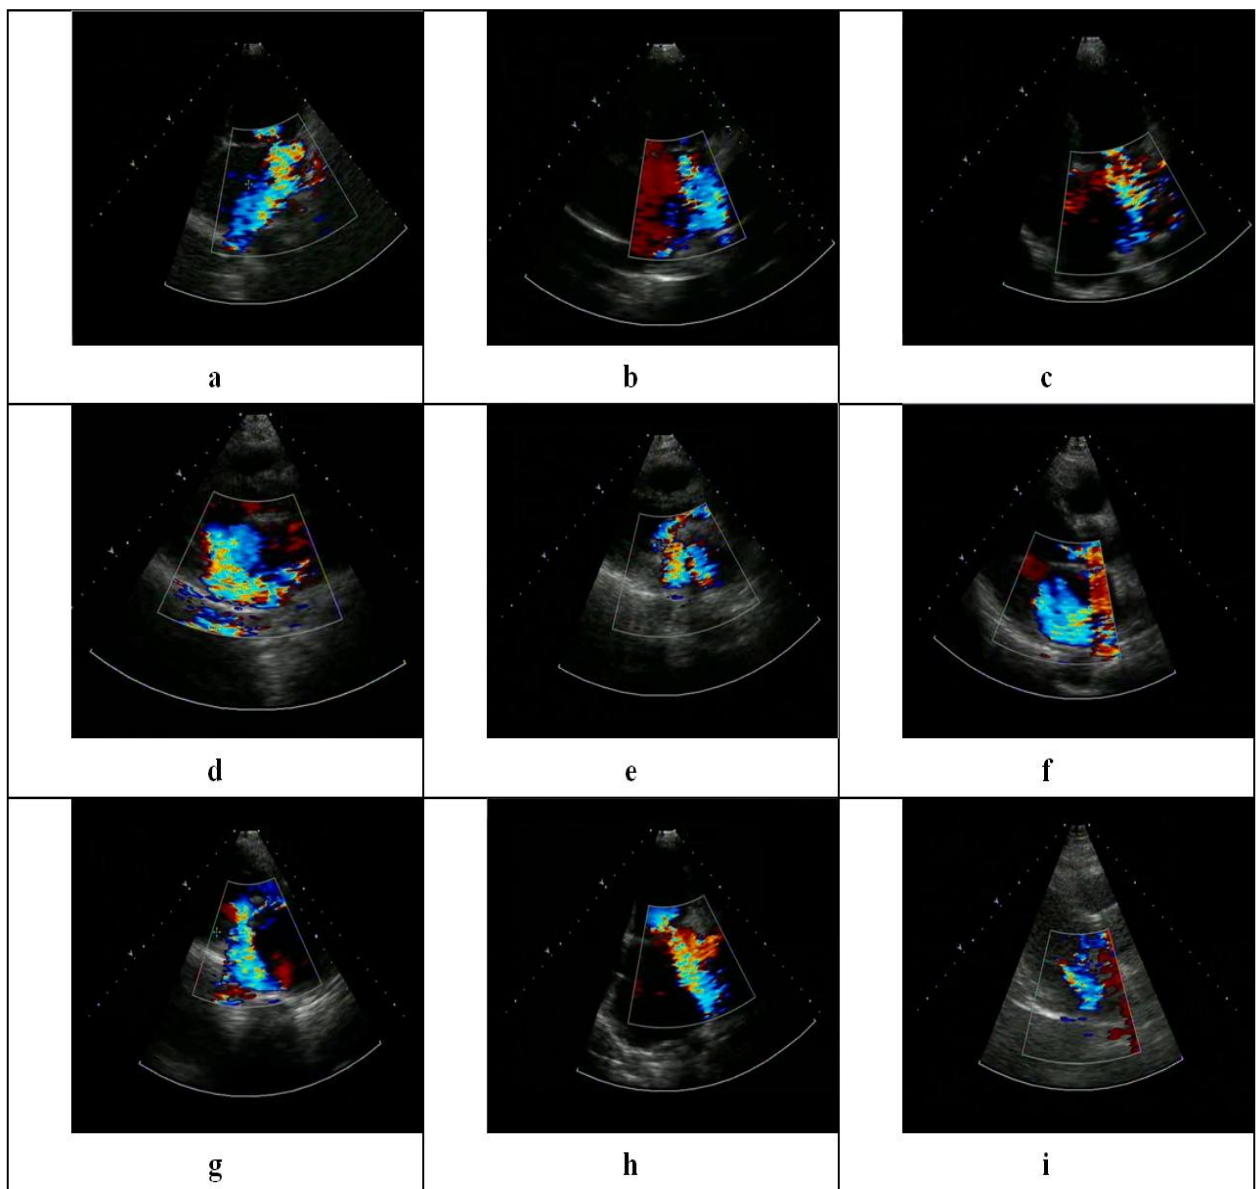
Color Doppler Images with Mitral Regurgitation
